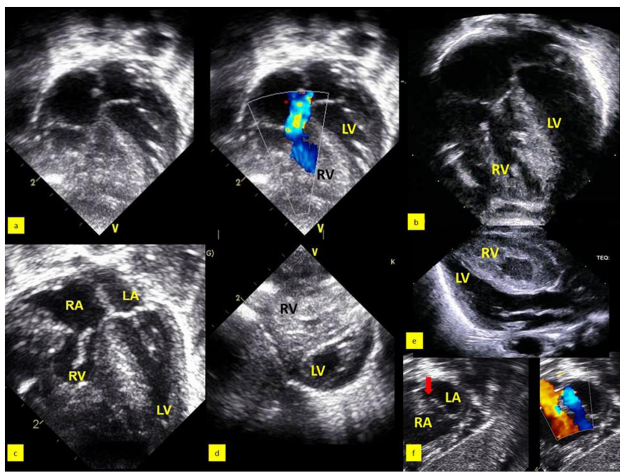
Representative images of few neonates, showing severe right ventricular hypertrophy. a,b,c: Apical 4 chamber views showing severe right ventricular hypertrophy, obliteration of RV apex (bipartite RV), tricuspid regurgitation, and normal left ventricular dimensions. d- parasternal short axis view, and e- parasternal long axis view: showing severe right ventricular hypertrophy and normal left ventricular dimensions. f- subcostal view showing right to left shunting across patent foramen ovale (red arrow).
